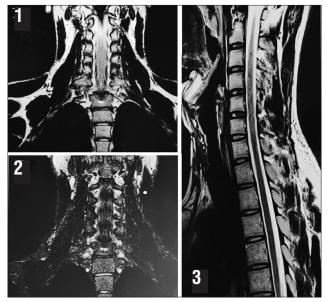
The contour, trace and signal intensities of the roots, trunks and cords were normal in the brachial plexus and cervical MRI.
